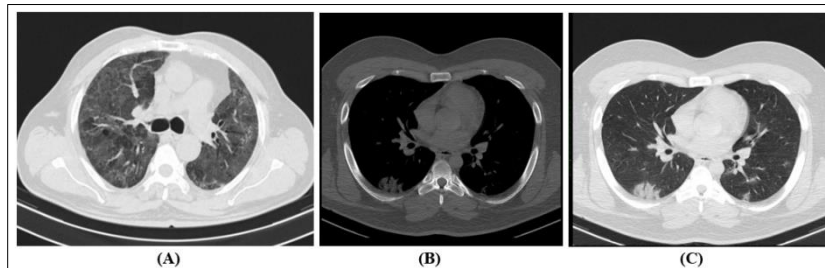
Image (A) Non contrast chest CT of 67-year-old RT-PCR positive male patient with CT score of more than 18. Axial section at the level of carina shows diffuse, non-segmental ground glass opacities with areas of interstitial septal thickening within giving crazy paving appearance with few sub-pleural bands noted bilaterally. Image (B) and (C) Non contrast chest CT of 25-year-old RT-PCR positive male patient. [B. Lung window, C. Soft tissue window] Axial sections show peripherally located focal area of consolidation with air-bronchogram in right lower lobe.
